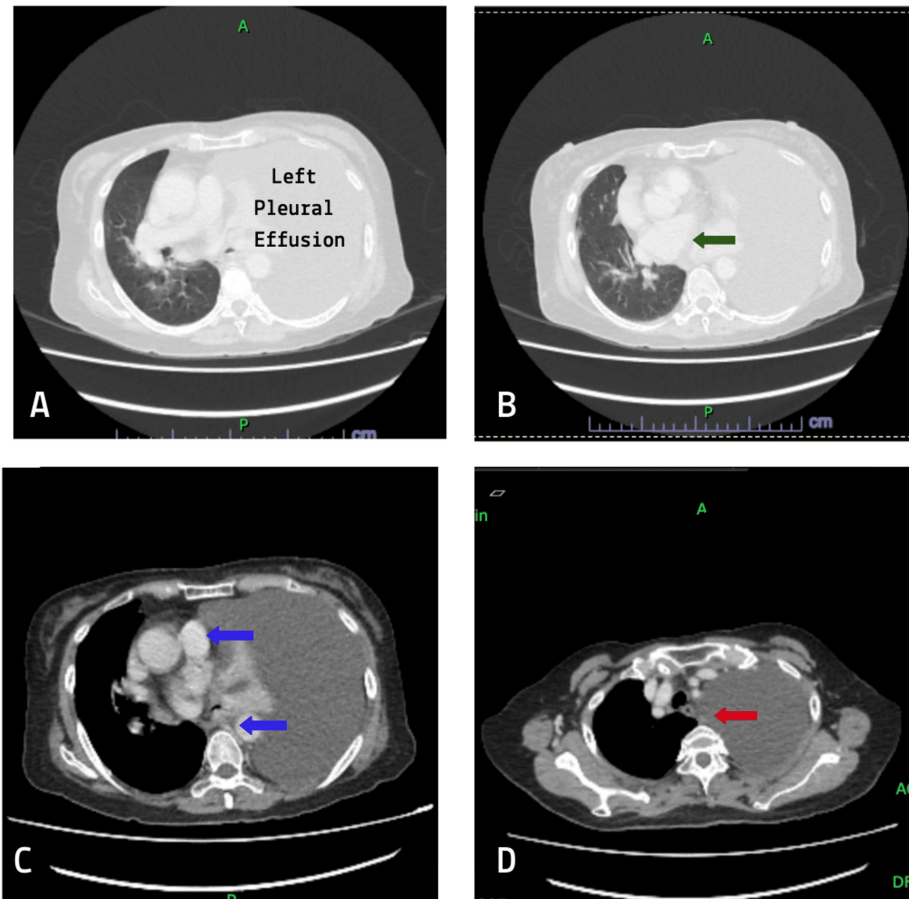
Axial CT scans of the thorax demonstrating a large left pleural effusion with passive compression of the underlying lung (A), mediastinal shift to the right due to mass effect from the effusion (green arrow, B), prominent mediastinal lymphadenopathy suggestive of possible lymph node metastases (blue arrows, C), and a small, indeterminate right upper lobe pulmonary nodule (red arrow, D)
